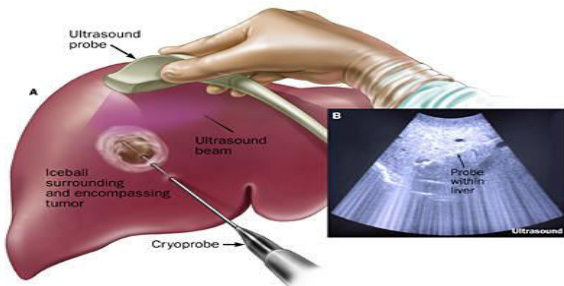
A) Cryosurgery of liver cancer B) Ultrasound image showing the cryoprobe
